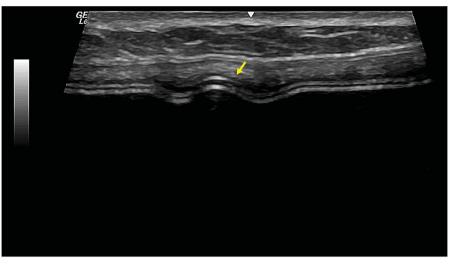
Ultrasonographic view of a silicone implant. Midline indicator or ridge (yellow arrow) was confirmed as being malpositioned more than 30 degrees off of the midline axis.
